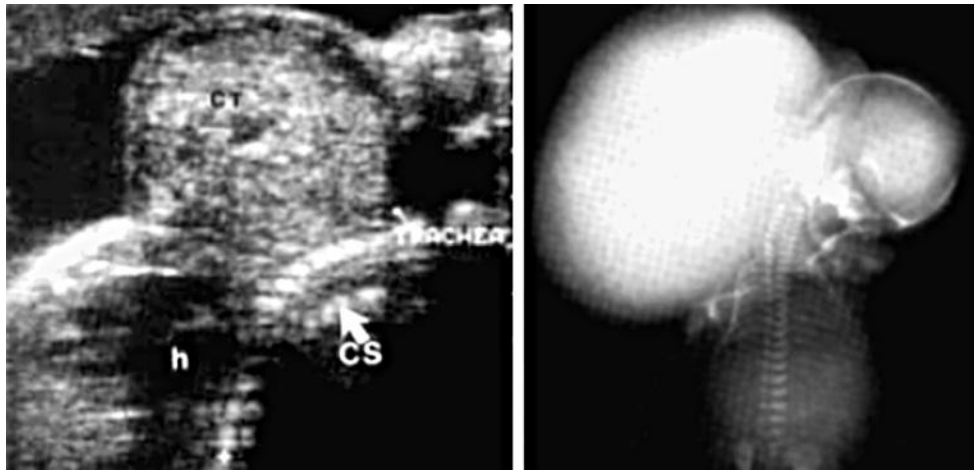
Large cervical teratoma (CT). CS, cervical spine; h, heart.
